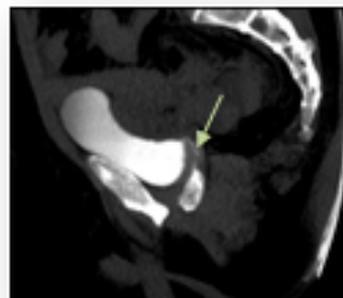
Axial Excretory phase and Sagittal MIP images from a CT Urography study showing opacification of the vagina by excreted contrast in bladder. Sagittal MIP reconstructed image shows the fistulous tract (white arrow).
